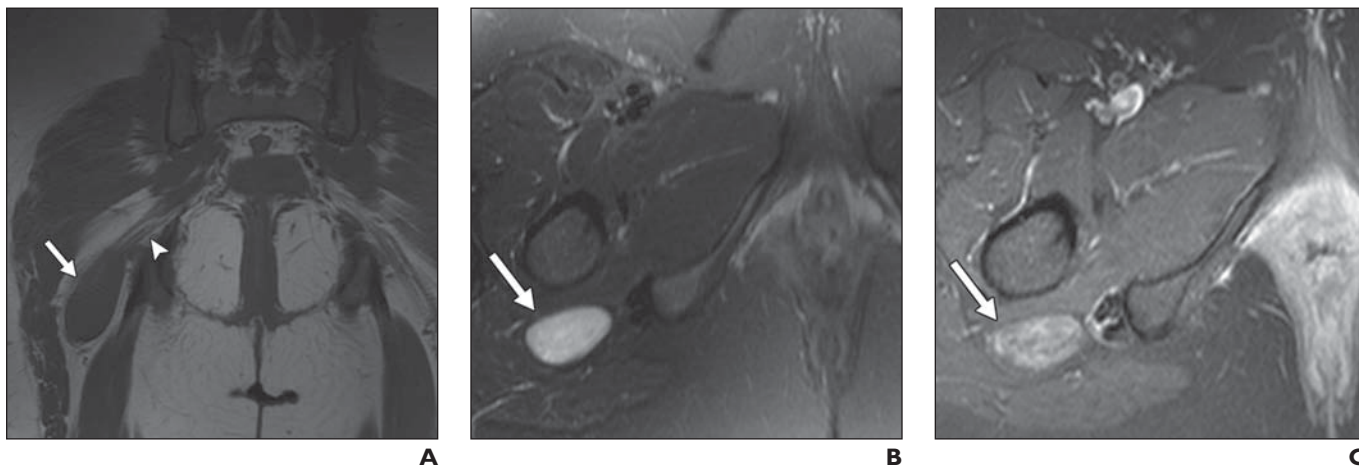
37-year-old woman with solitary neurofibroma. A, Coronal T1-weighted MR image of pelvis shows elongated mass (arrow) with signal intensity similar to that of muscle arising from right sciatic nerve (arrowhead). B, Transverse fat-suppressed T2-weighted MR image shows mass (arrow) with uniform hyperintense signal. C, Transverse fat-suppressed T1-weighted MR image obtained after IV administration of gadolinium chelate shows heterogeneous enhancement of mass (arrow).
